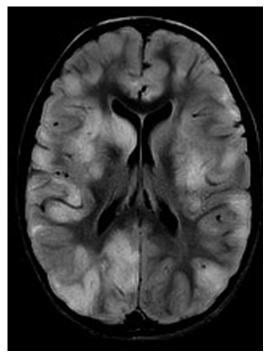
T2 Axial FLAIR image showing extensive demyelinating lesions involving both the gray and white matter in ADEM.
